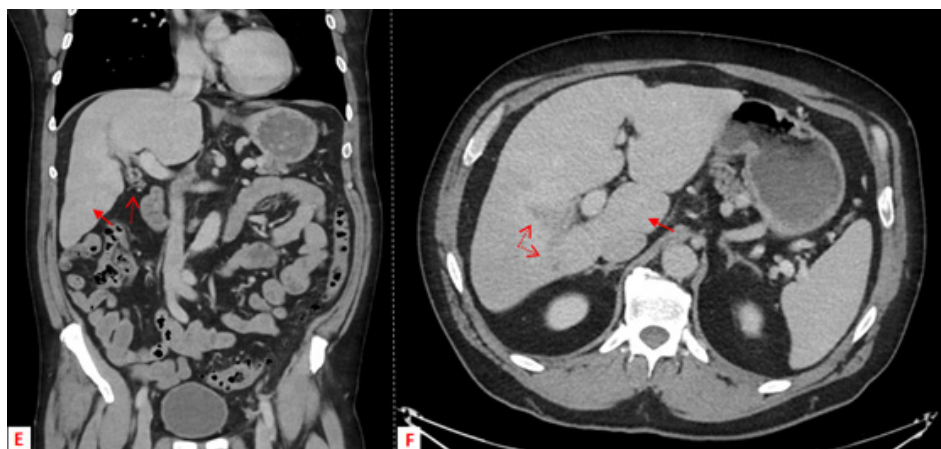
In the contrast-enhanced computed tomography scan, in the venous phase, in the coronal plane, performed 1 month later, slightly heterogeneous parenchymal enhancement was highlighted in segments 6 and 7, with practically complete resolution of the previously described hypovascular nodules (filled arrow in E). Partial resolution of the portal vein thrombosis also occurred, and in this follow-up CT study, only chronic changes were identified, with a reduction in the caliber of the anterior and posterior branches of the right main portal branch (dashed arrows in F) and the appearance of collateralization (dashed arrow in E). Relative hypertrophy of the caudate lobe was also observed (filled arrow in F), consistent with chronic liver disease.
